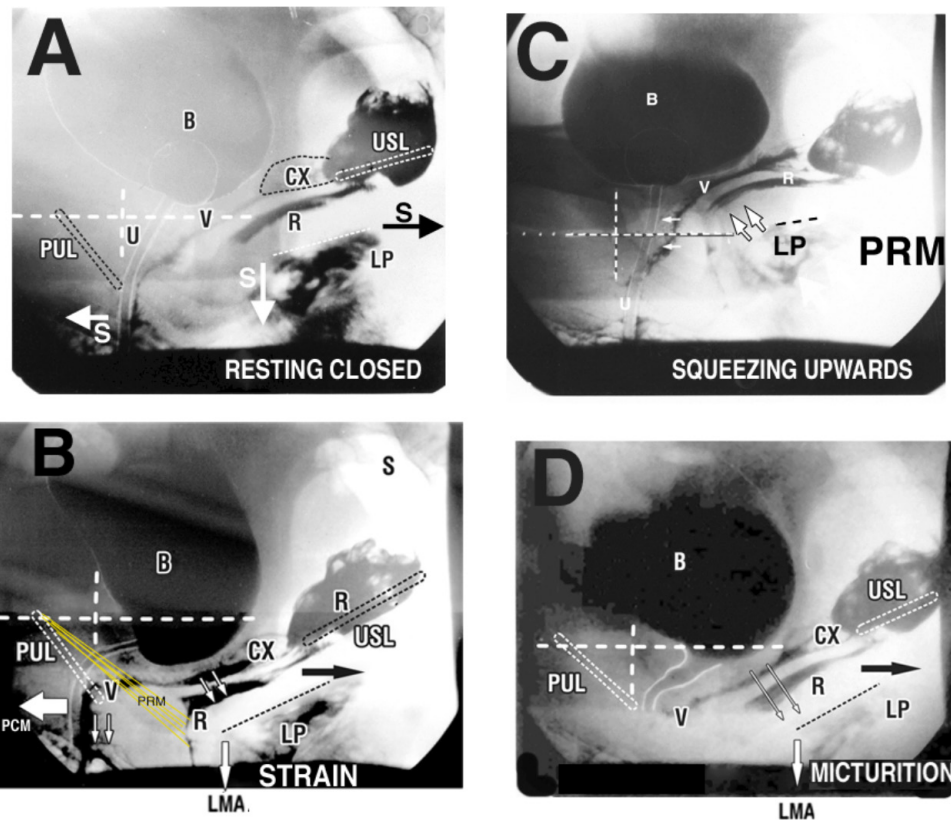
Role of the levator plate in bladder/anorectal closure and micturition. Sitting X-rays Vertical and horizontal lines are bony co-ordinates; A: RESTING CLOSED note S= directional slow twitch muscles as in B. radio-opaque dye inserted into bladder (B), rectum (R), vagina (V) and levator plate (LP). B: STRAIN; note 3 fast-twitch opposite directional forces (arrows) activated by strain; indentation of rectum by PRM; downward angulation of LP by LMA rotates bladder "B" around PUL and rectum "R" around PRM for closure; D: MICTURITION note 2 directional forces for micturition (forward force relaxed), angulation of LP by LMA pulls open posterior urethral wall; C: SQUEEZING UPWARDS: Note LP lifted upwards and forwards from below (by puborectalis PRM). PCM=pubococcygeus; LMA: conjoint longitudinal muscle of the anus. PCM: pubococcygeus muscle; PUL: pubourethral ligaments; USL: uterosacral ligaments. CX: cervix. From Petros PE [ref].
